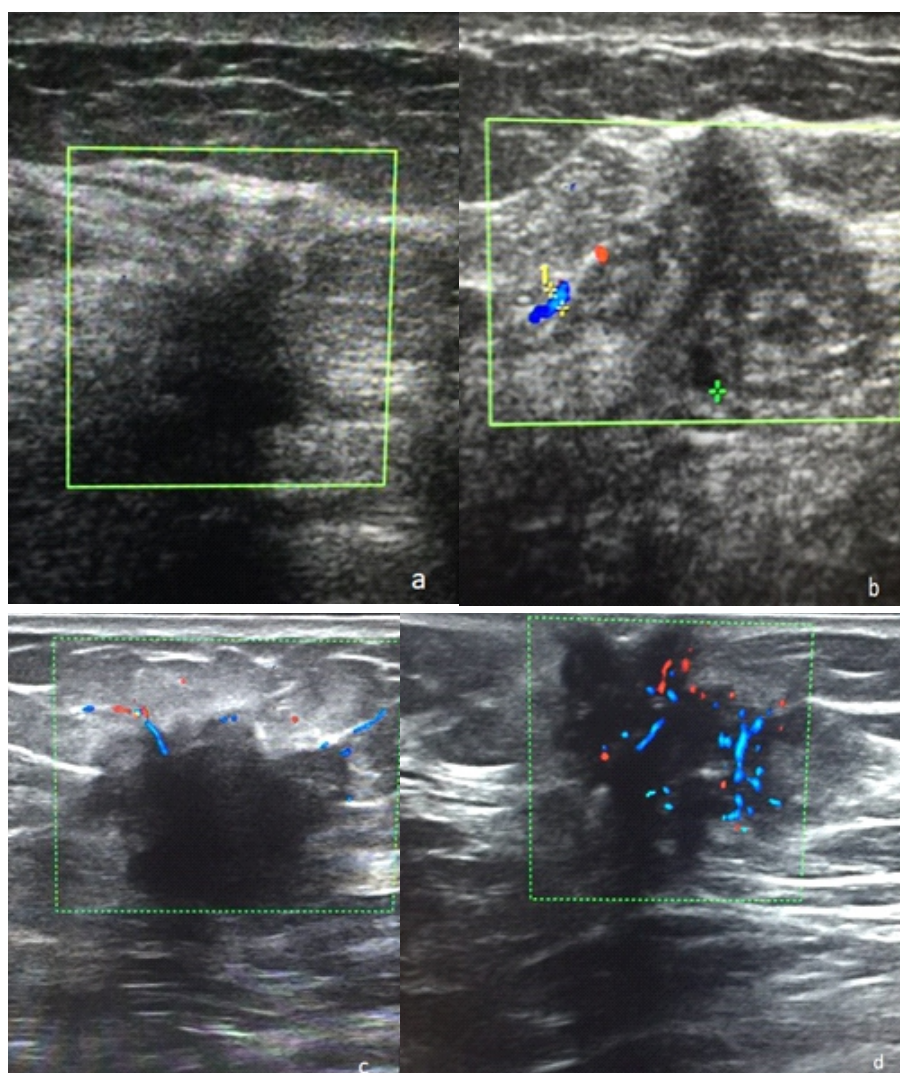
Different patterns of color Doppler flow were seen among the patients in this study. a) No flow; b) Feeder; c) Peripheral flow; and d) Entire mass flow.
